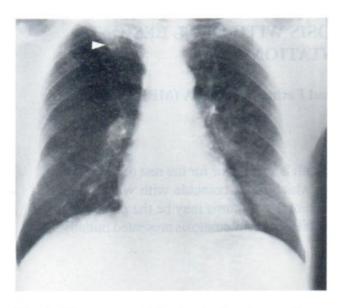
Chest x-ray (PA view) showing a large nodular lesion in the posterior segment of the right upper lobe.
